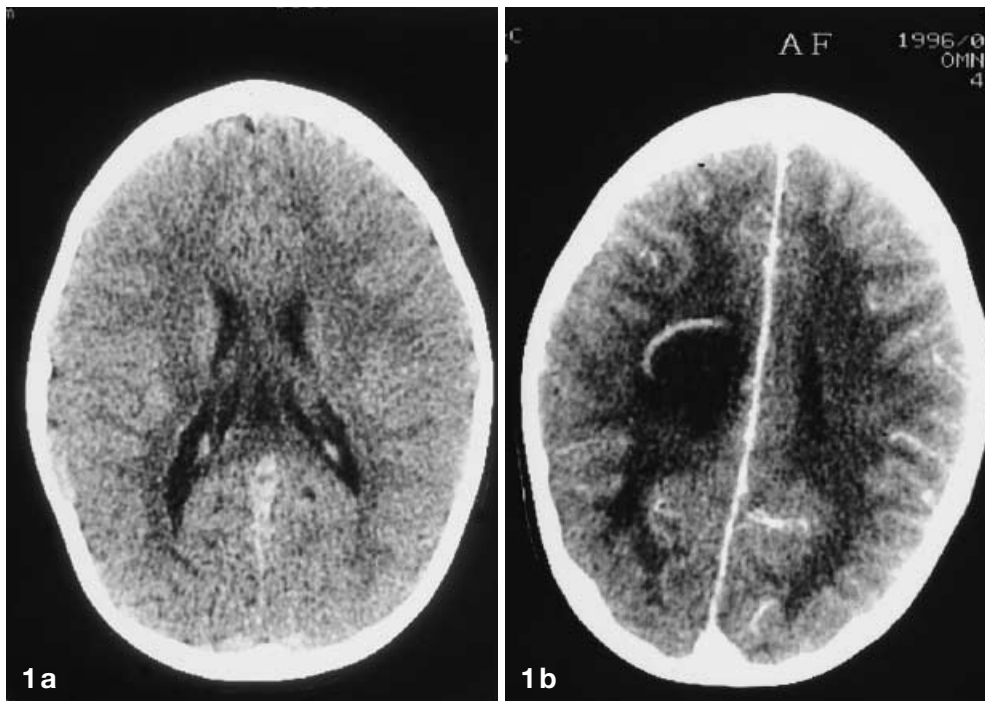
a, b Axial contrast-enhanced CT. a Through the bodies of the lateral ventricles and splenium of the corpus callosum. There is no abnormality. b Through the centrum semiovale. There is a large, low-attenuation, partially ring-enhancing mass in the right frontoparietal white matter
